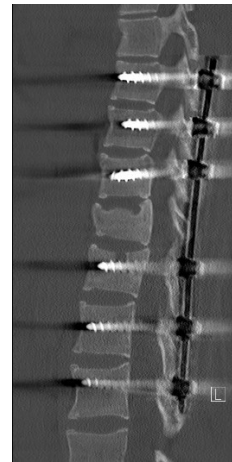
Post-operative CT showing healing of the fracture and stability of the pedicle screws 6 months after surgery
